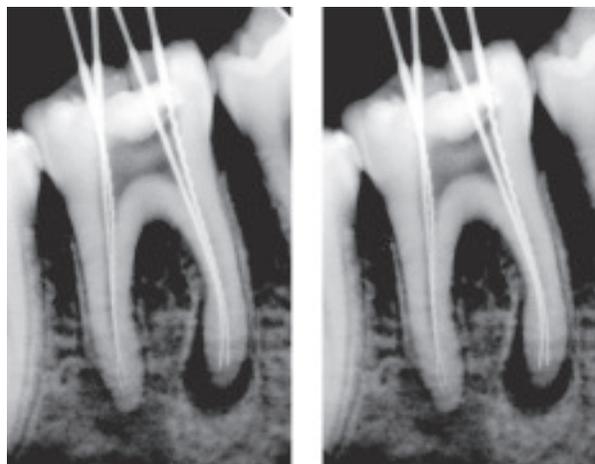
WLM X-ray (RVG-View)
